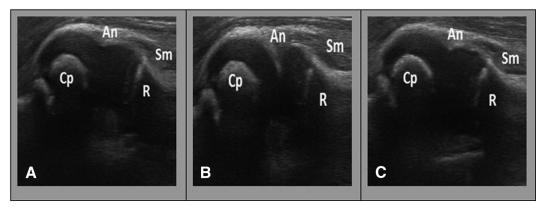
Ultrasonographic images of the patient's unaffected and affected elbow joints. (A) Normal view of the elbow joint shown in the unaffected elbow; the annular ligament is around the radial head and outside the joint space. (B) Pathologic view of the SRH shown in the affected elbow; the annular ligament is in the joint space. This is the pathologic "hook sign" formed by displacement of the annular ligament into the joint space together with some part of the supinator muscle. (C) Postreduction view of the affected elbow after a successful reduction; note the loss of hook sign. An = annular ligament; Cp = capitellum; R = radial head; Sm = supinator muscle; SRH = subluxation of the radial head.
